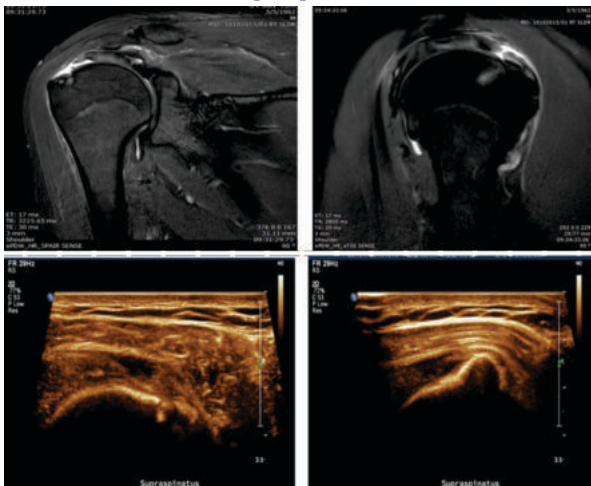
(a,b) MRI coronal and sagittal images showing full thickness tear of supraspinatus tendon at insertion site. (c,d) USG images in transverse and oblique showing the same.
